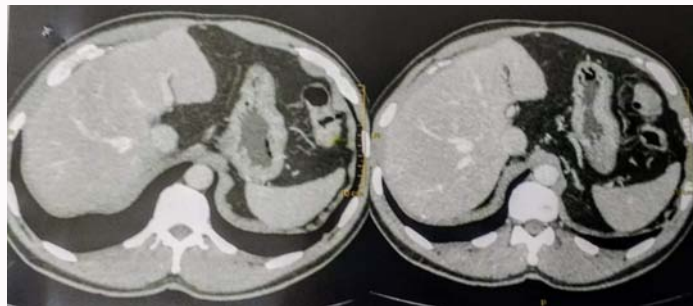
Postoperative Contrast-enhanced CT (18 months after Caudate Lobectomy)- Absence of the Caudate Lobe.
